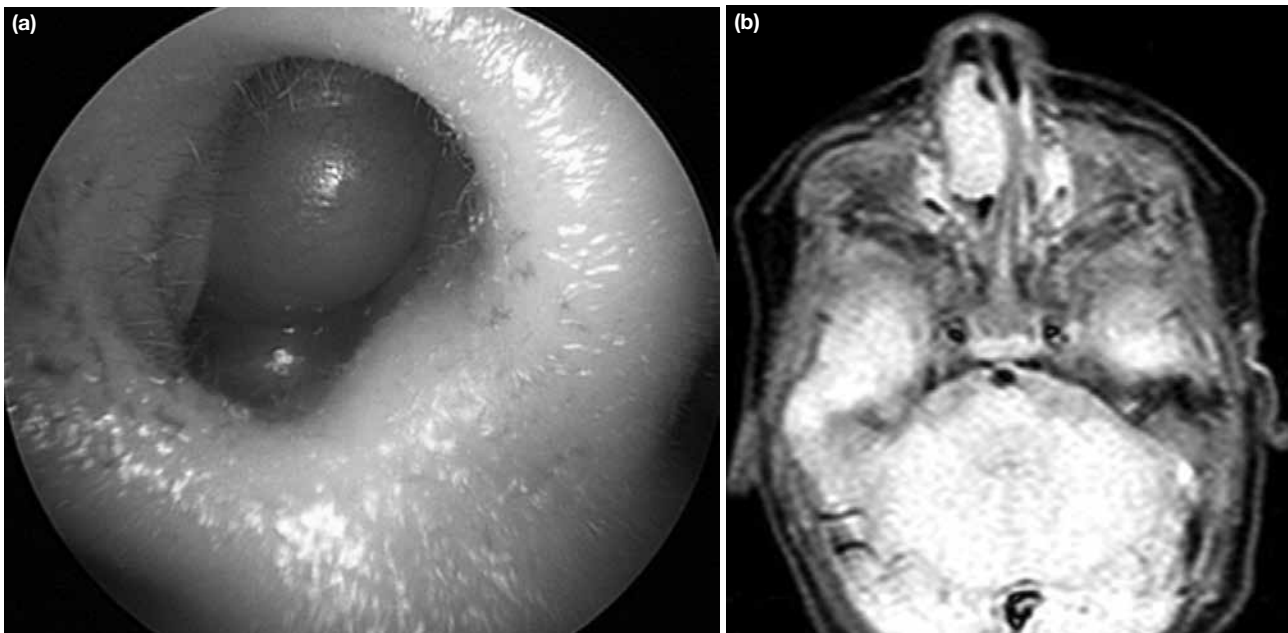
a, b. The mass filling the right nasal cavity (a). Preoperative MRI of the patient in axial plan (b).
